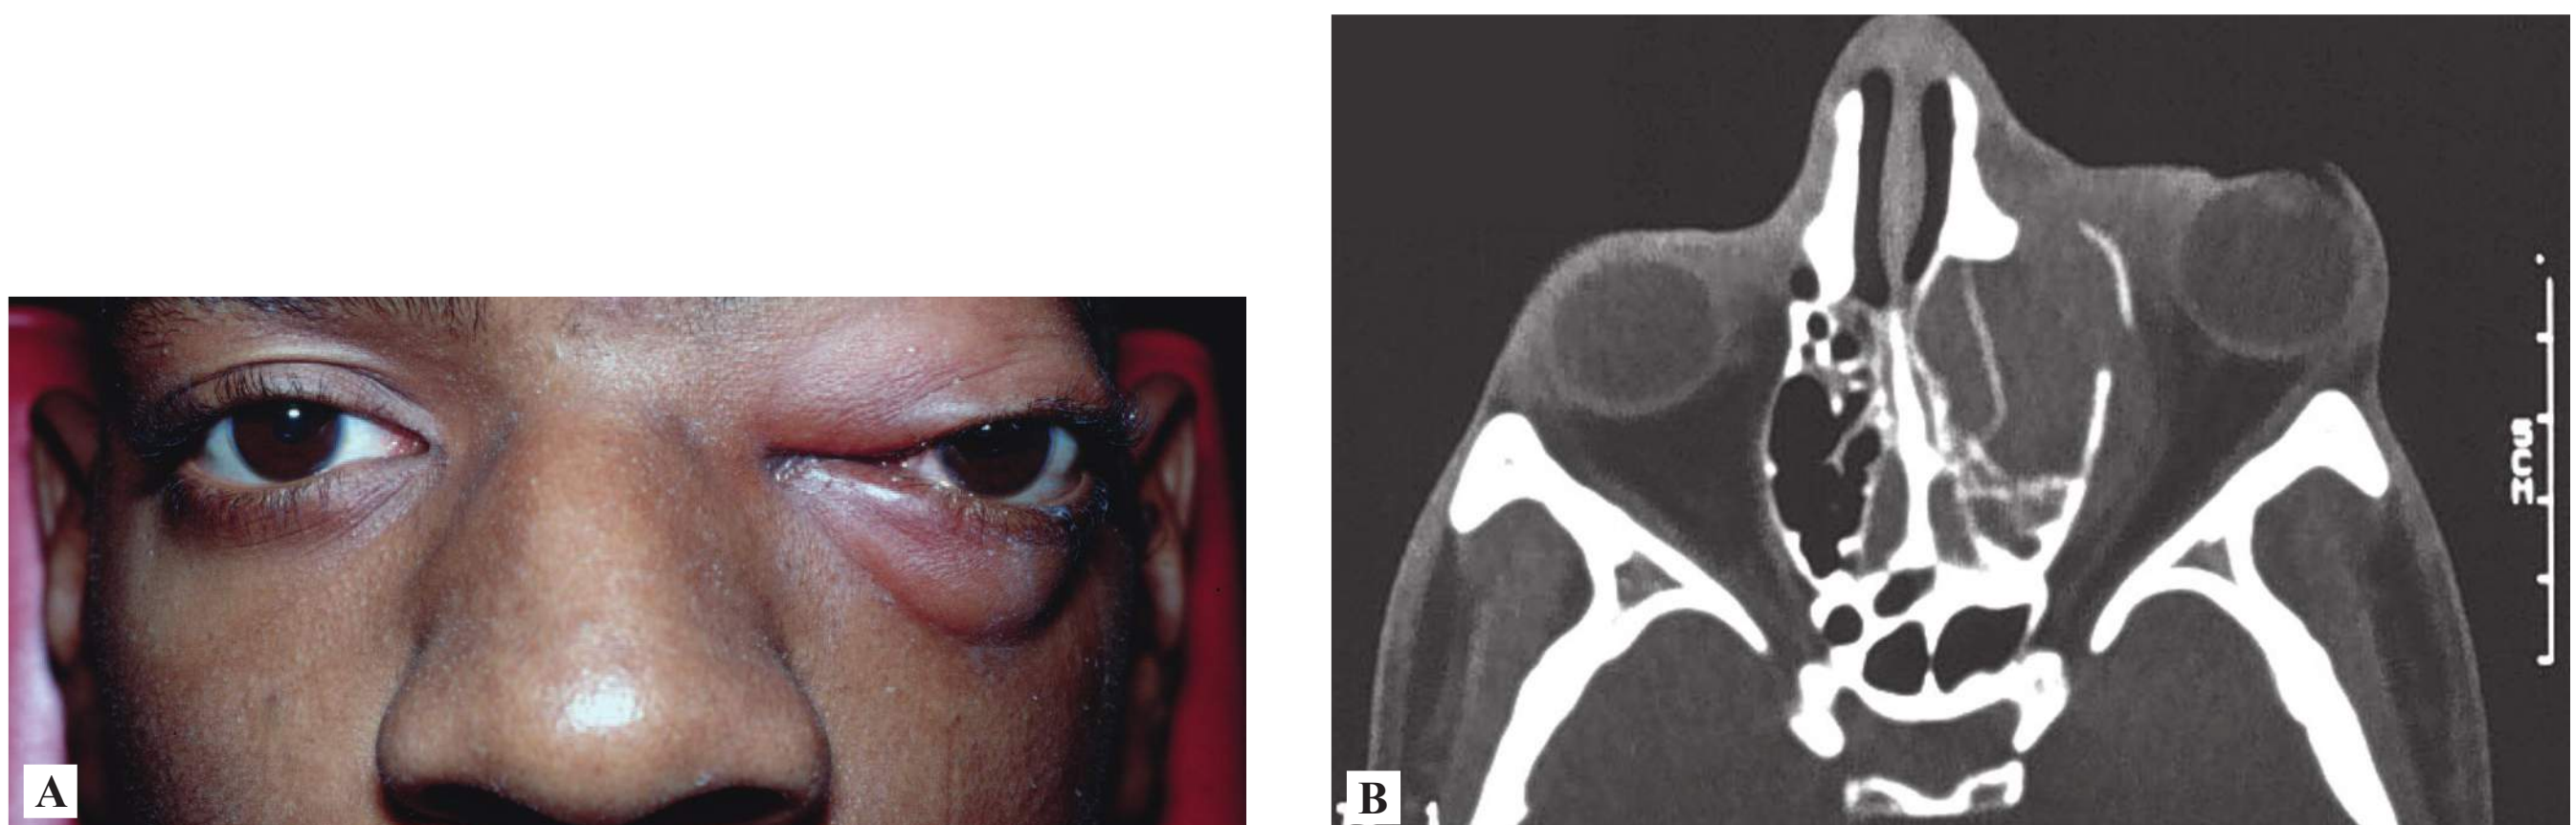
■ Orbital Cellulitis. Left ethmoid sinusitis with extension into the orbital space, periosteal abscess formation, and proptosis is seen in this patient (A) and on CT (B). (Photo contributor: Lawrence B. Stack, MD.)
